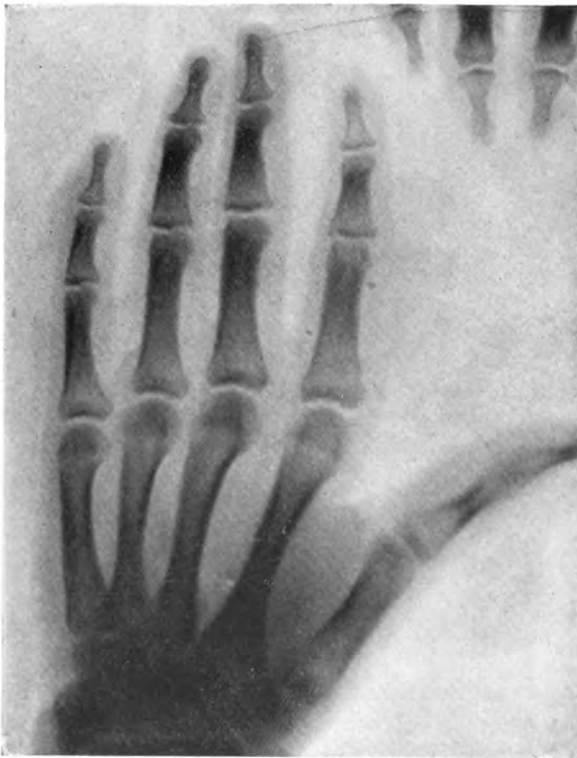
Necrosis of proximal phalanx of thumb. Showing how slightly the radiographic appearance may vary from the normal.
